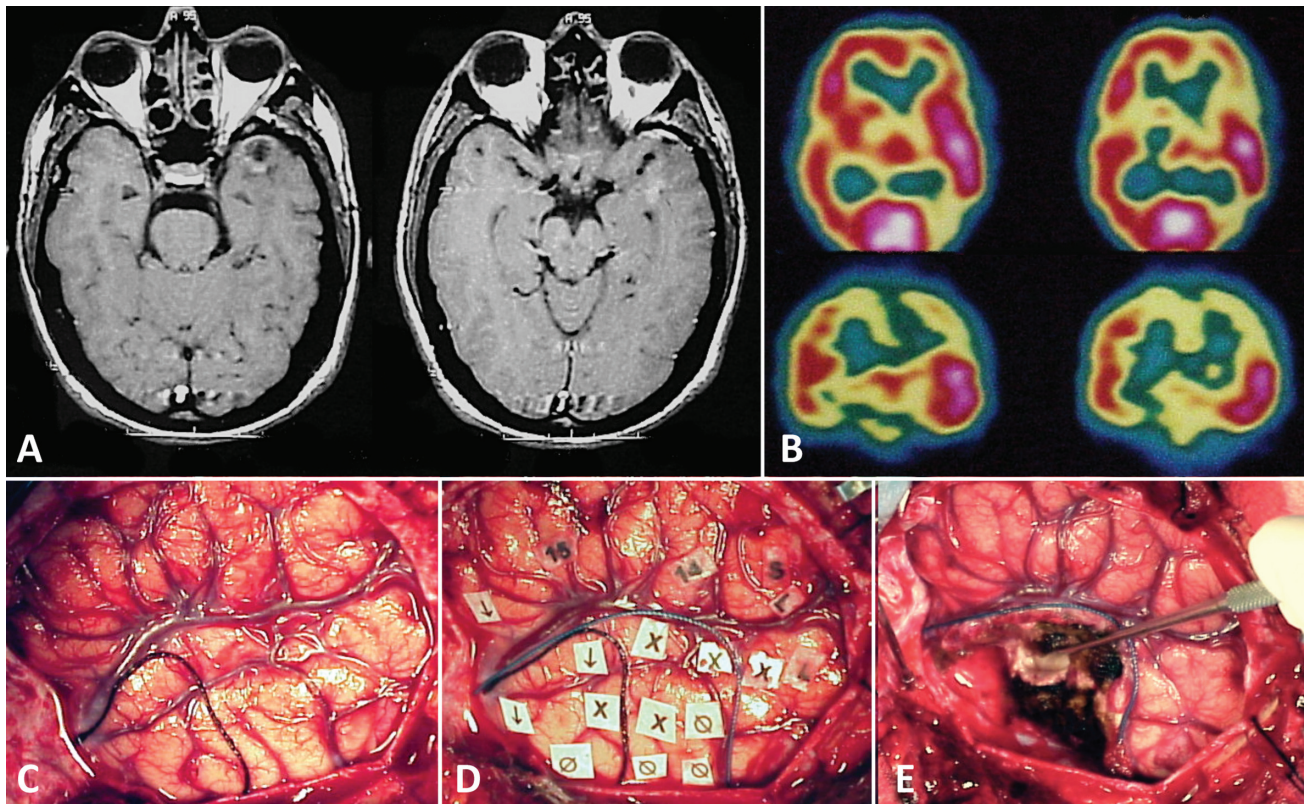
(A) Preoperative, contrast-enhanced T1-weighted MRI reveals hypointense lesion in left temporal lobe pole of patient with refractory epilepsy. (B) Ictal aspect scan showing a bright area at the left temporal lobe. (C) Intraoperative photo: Exposure with delimitation of the area to be resected with silk thread. (D) Intraoperative photo: After electrocorticography registry was performed, discharges (X) were noted beyond the tumor site. Since the language areas (L) were more posterior, a 5 cm temporal cortex resection could be made from its pole. ↓: attenuation; ∅: normal electrographic tracing. (E) Intraoperative photo: final aspect, revealing an increase of the resected area compared with the initial planning. The patient became seizure free with no transitory or definitive deficit.
